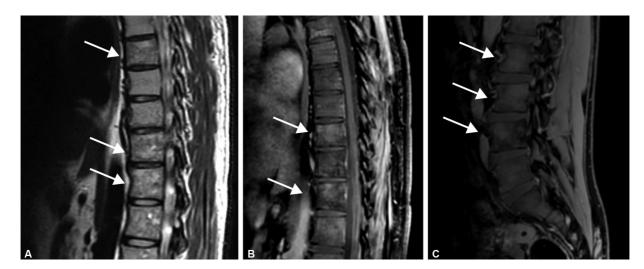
(A–C) Sagittal T2-weighted and post-contrast sagittal T1-weighted images (5 months post-surgery) showing altered signal intensity enhancing lesions in multiple vertebral bodies (arrows).
